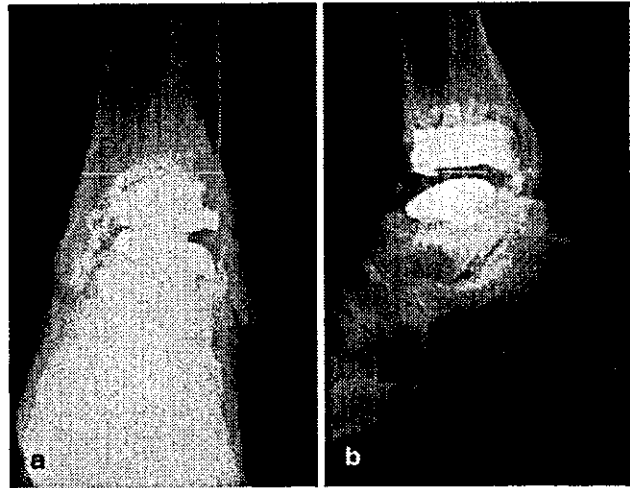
a Anteroposterior radiograph showing migration of the tibial component. b Lateral radiograph showing collapse of talus after TNK arthroplasty
